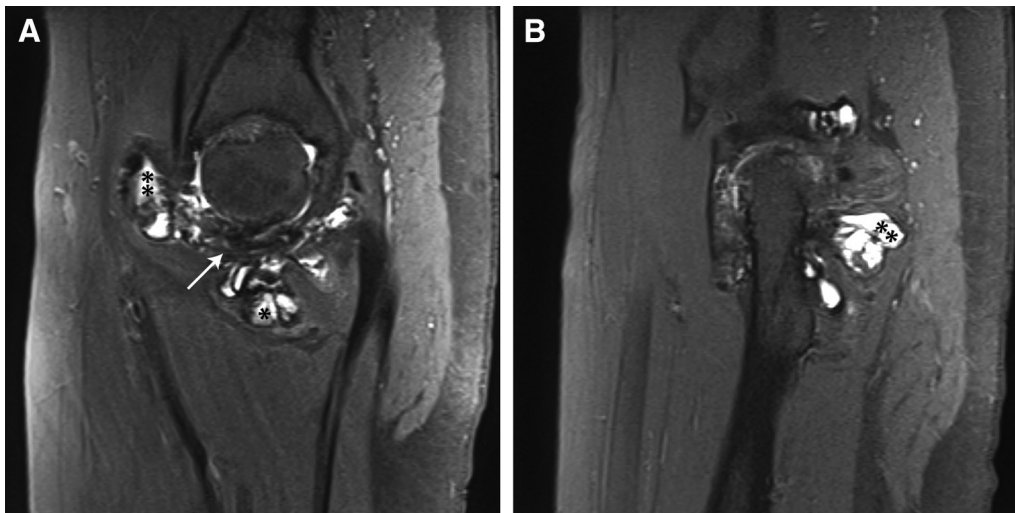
(A) Magnetic resonance imaging (MRI) T1-weighted sagittal image of the right hip, demonstrating hypointense “blooming” (white arrow) artifact caused by the hemosiderin in the hyperplastic synovium. In addition, the diffuse pigmented villonodular synovitis lesions have infiltrated the entire joint space, both the central compartment (asterisk) and peripheral compartment (double asterisk), and penetrated into the joint capsule. (B) MRI T1-weighted sagittal image of the right hip, demonstrating a significant amount of posterior invasion (double asterisk) of the peripheral compartment. Photos courtesy of the author, Scott D. Martin.
